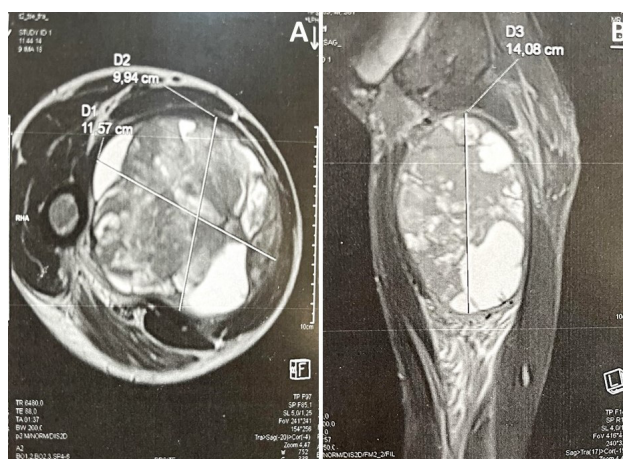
A) Axial and B) Sagittal MRI of the right thigh revealing a well-defined tissue mass originating from the adductor magnus muscle. The mass exhibited a heterogeneous solid-cystic signal, predominantly showing signs of haemorrhage, and demonstrated heterogeneous enhancement after gadolinium injection. It measured 10 × 11.5 cm in the axial plane and extended over a height of 14 cm in the sagittal plane, with no signs of extension into the surrounding muscular and bony structures.
